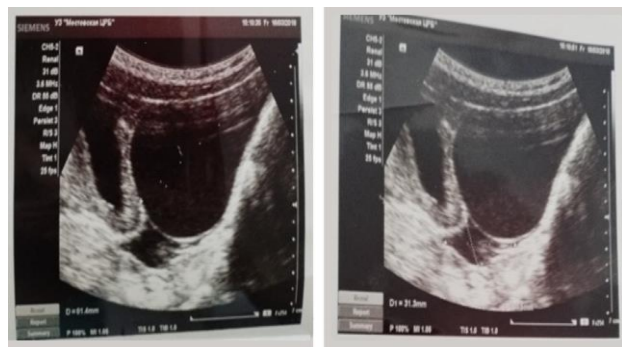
A bilocular cyst on abdominal ultrasound of a 5-year-old child.
